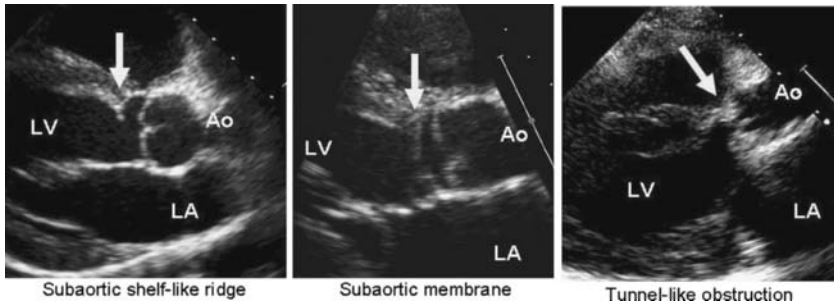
Examples of types of SAS as viewed in the parasternal long-axis view by transthoracic echocardiography. LV, left ventricle; LA, left atrium; Ao, aorta.
